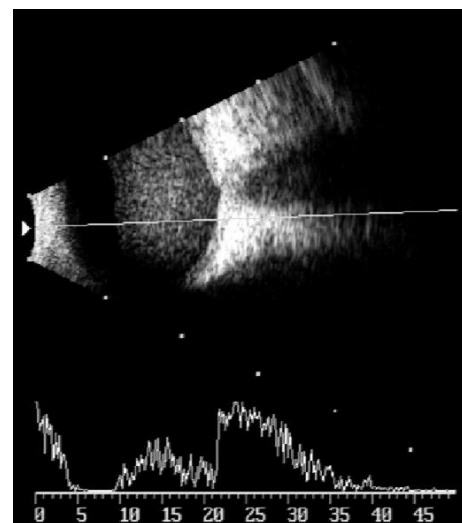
A and B scan ultrasound of vitreous hemorrhage.
